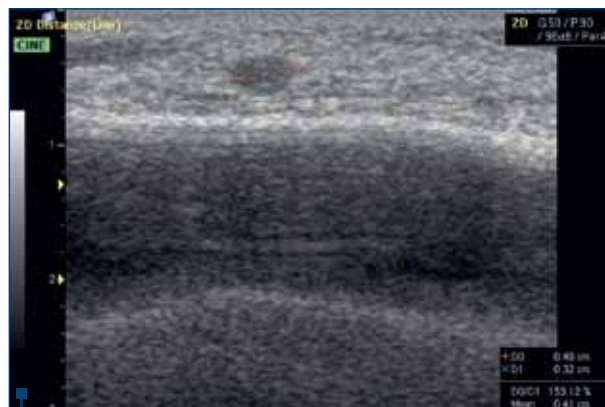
Ultrasound aspect of a solid mass, homogenous, with regular shape, oval, with long axis parallel to the skin, well defined (benign lesion, located above the implant)
